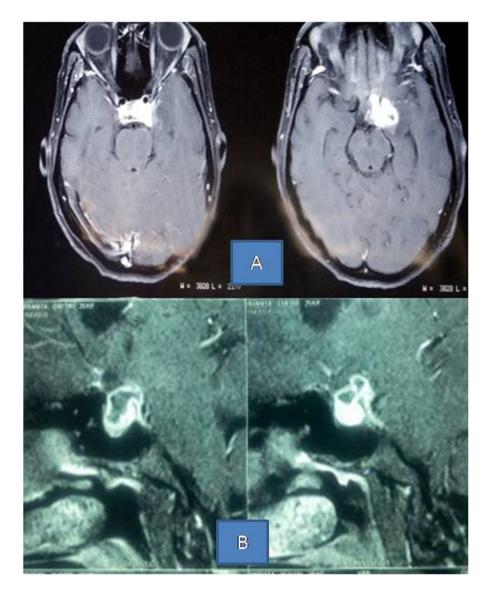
(A) Axial section MRI brain T1 contrast study showing a conglomerated heterogenous rim, nodular enhancing lesion in the left parasellar region with dense enhancing basal exudates encasing the ipsilateral internal carotid artery. (B) Sagittal section MRI brain T1 contrast study showing ring enhancing lesion involving optic chiasma with enhancement of suprasellar structure.
